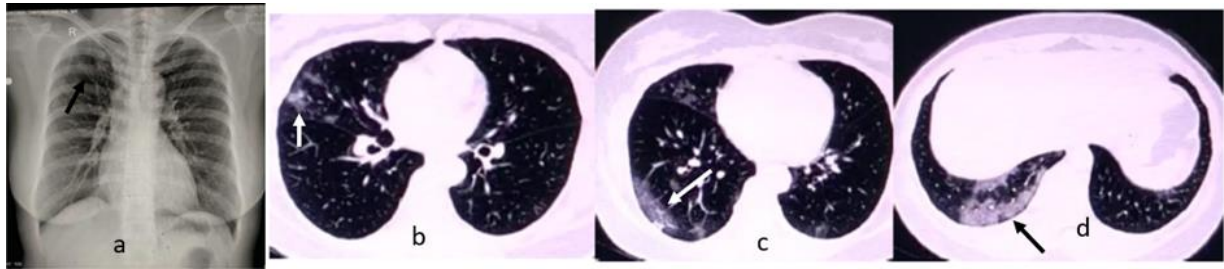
(case 1) CXR shows the right posterior upper lung fibrosis (a). HRCT shows multifocal sub pleural GGO in the middle and posterior right lung lobe (b.c). Subpleural nodule in the left lower lung lobe (head arrow c) and crazy paving found in the right subpleural posterior lung lobe (arrow d) suitable with minimal typical COVID 19
